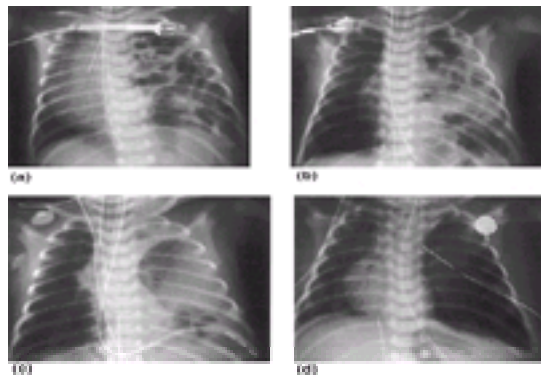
(a) Initial chest radiograph obtained shortly after birth in an infant with congenital diaphragmatic hernia. The infant required intubation in the delivery room. Note air-filled intestines in the left thoracic cavity and shift of the mediastinum and heart to the right following resuscitation. (b) One hour later after the stomach has been decompressed and the infant ventilated with small tidal volumes the mediastinum has returned to a more normal midline position. (c) The infant was managed with delayed surgery. Forty-eight hours after birth, continued improvement in decompression of the intestines is seen as well as appearance of some pulmonary tissue on the left side. This infant suffered severe deterioration in his respiratory status by conventional ventilation resulting from development of pulmonary hypertension. He required extracorporeal membrane oxygenation for 5 days, after which he was returned to standard ventilation and underwent surgical repair without difficulty. (d) Chest radiograph following repair in this infant who was then readily weaned from the ventilator.
